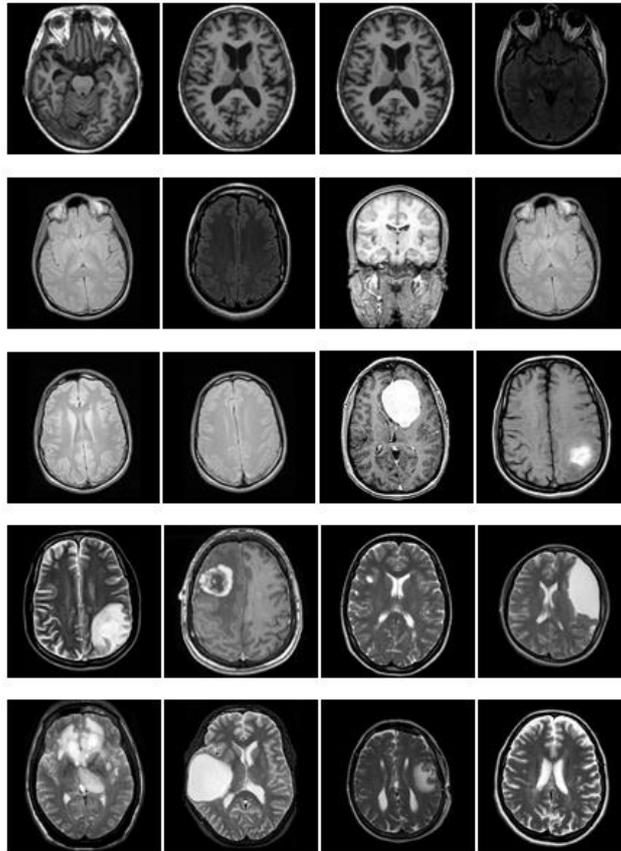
Input MRI Normal and Abnormal Brain images
